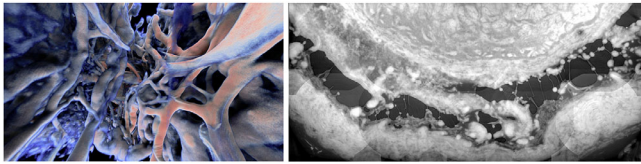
Micro-computed tomography images in a human demonstrated trabeculae and septae in the subarachnoid “empty” space.
